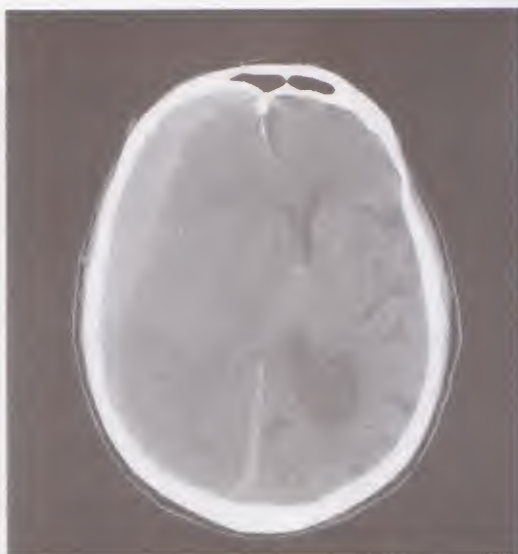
CT brain showing a peripheral high-density extra-cerebral collection within the subdural space compressing and displacing the right cerebral hemisphere denoting an acute subdural hematoma
